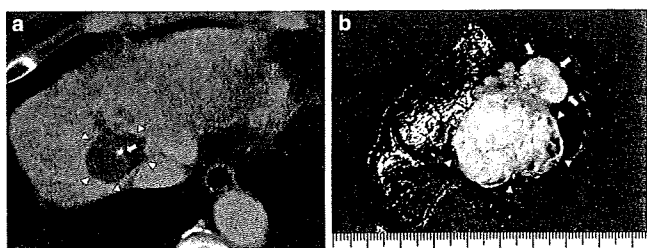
(a) Abdominal CT showing a low-density cystic mass with an enhancing wall (white arrowhead) and calcification (blue arrow) in segment VIII of the liver, but no sign of dilatation of the intrahepatic bile ducts. (b) Gross appearance of the tumor, showing a cystic area (white arrowhead) and a solid area (yellow arrow).
